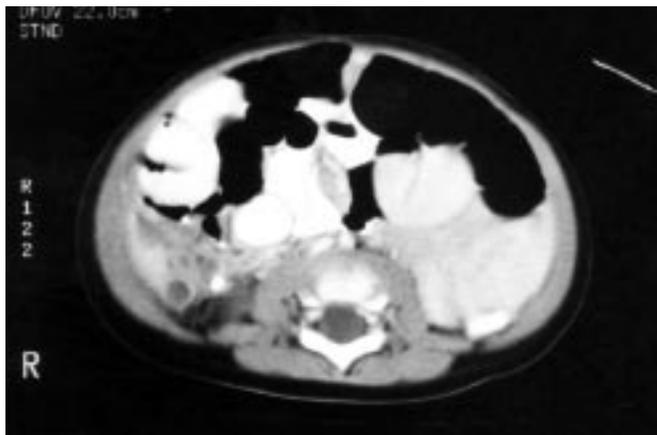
Examples of CT Findings in Acute Appendicitis
